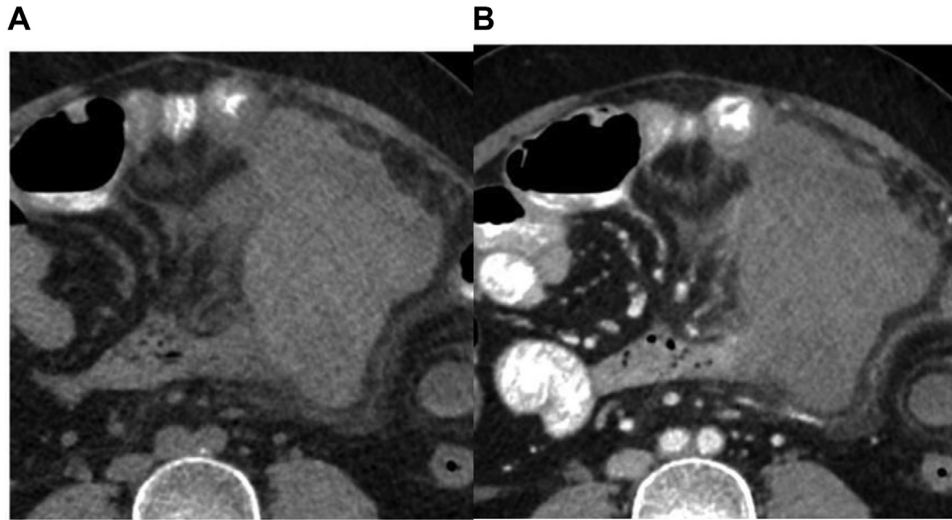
Axial plain (A) and contrast enhanced (B) CT images show an ill-defined hyperdense lesion in mesentery in left paraumbilical/lumbar region with surrounding mesenteric fat stranding. There is no evidence of enhancement in the lesion on post contrast images.
